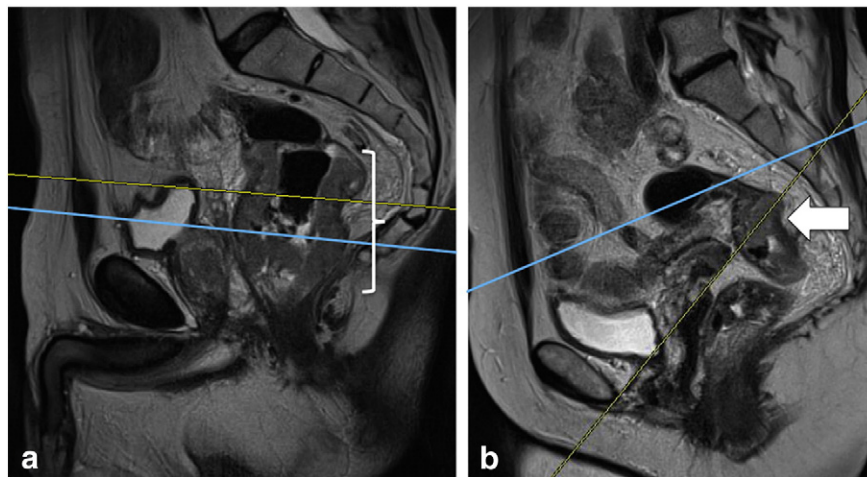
Sagittal large-FOV T2W TSE image (A) in a 64-year-old male undergoing local staging MRI of the pelvis for extensive annular rectal adenocarcinoma involving the middle rectum (tumor bracketed in A). The axial oblique imaging plane, depicted by a yellow cross-reference line (automatically generated in PACS), was determined to be correctly planned (in this study, defined as within 5° of the ideal plane determined by two abdominal radiologists). The ideal plane (as selected by two radiologists) is depicted by the blue line in A. Sagittal large-FOV T2W TSE image (B) in a 57-year-old female undergoing MRI for local staging of a more focal rectal adenocarcinoma (white arrow) in the high rectum demonstrates an example of incorrect axial oblique plane imaging (yellow line), as it differed by more than 5° compared to the ideal plane (blue line).
